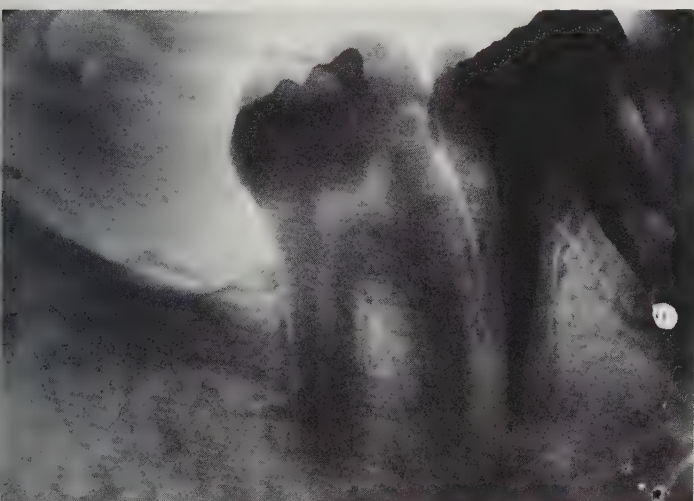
Periapical radiograph taken in November 1974 shows bone regeneration at site of previous lesion.
